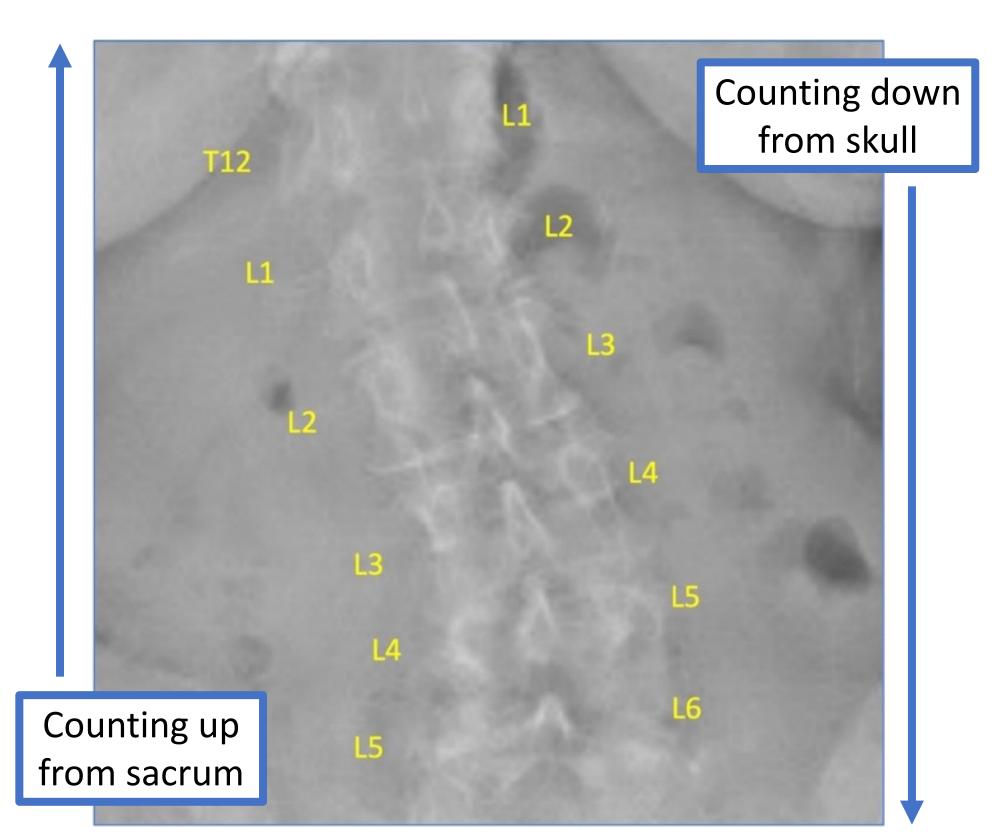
An AP lumbar radiograph demonstrating six non-ribbed presacral lumbar segments numbered in two different ways. The method on the right accounts for the more common abnormality (having 25 presacral mobile segments) rather than the less common abnormality (having 11 ribs)
